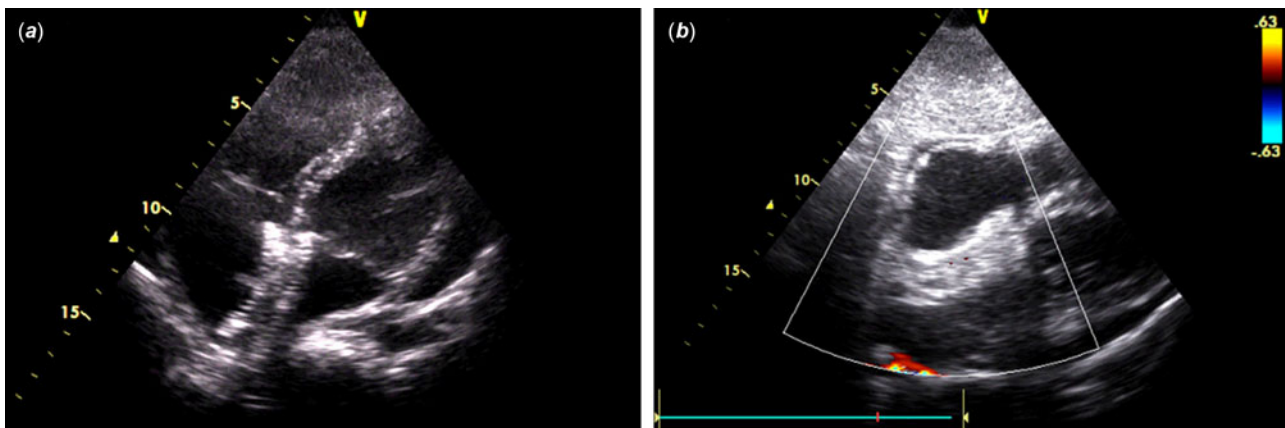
Minimal pericardial effusion with a well-positioned device in the four chambers (a) and sub-costal (b) TTE views. TTE = Transthoracic echocardiography.
